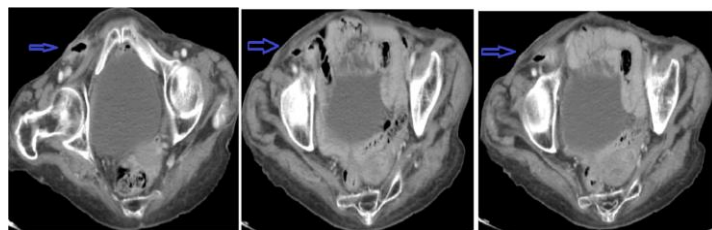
Abdominal computed tomography scan showing enterocutaneous fistula (arrow)
